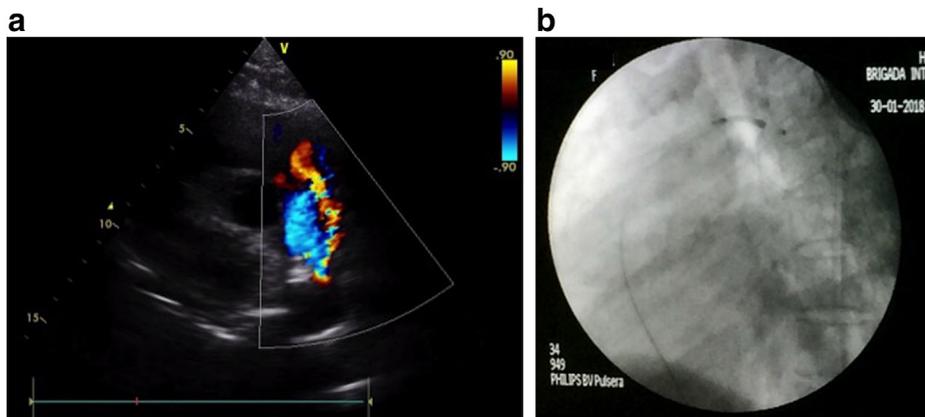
A: Trans-thoracic echocardiography showing long, thin, patent ductus arteriosus. B: Post-deployment fluoroscopy showing placement of ductal occlude, which was deployed from the venous side of the ductus arteriosus.
